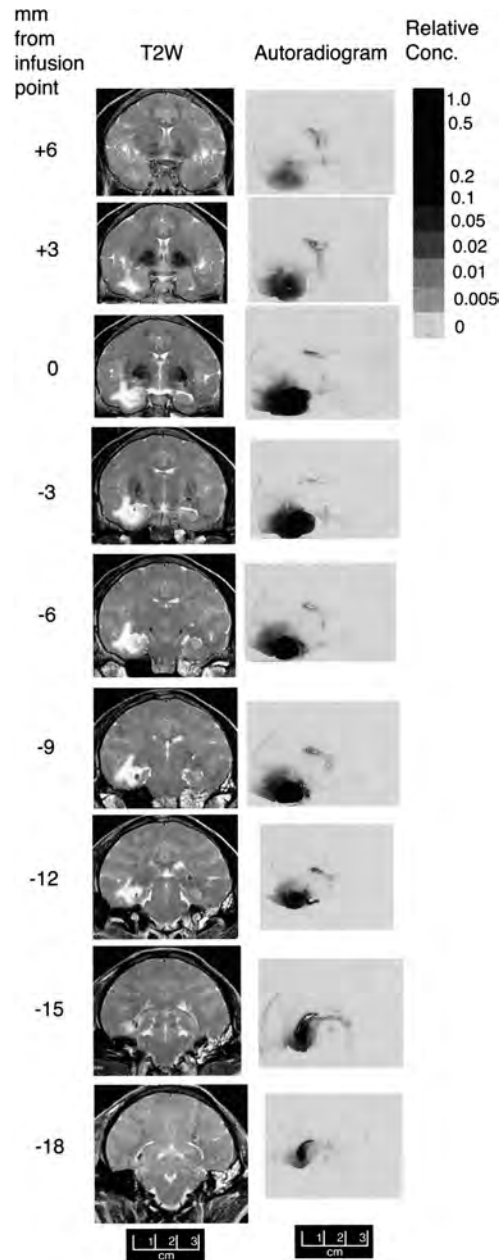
Several T<sub>2</sub>-weighted MR images and brain autoradiographs comparing coronal tissue sections. The part of the temporal lobe with increased fluid signal (white area) on the T<sub>2</sub>-weighted MR images corresponds to the part with the highest concentration of muscimol (dark gray area) on the autoradiographs.
